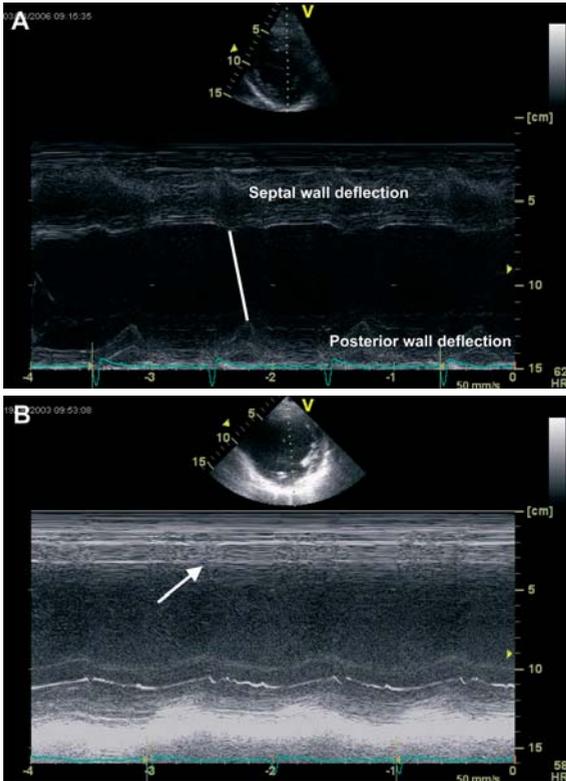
M-mode echocardiography
